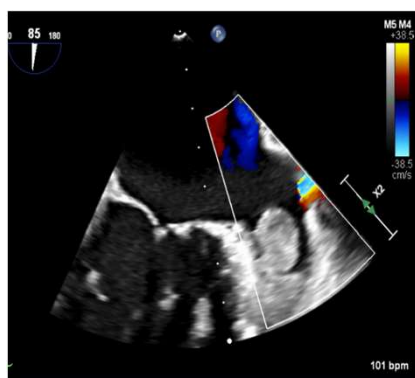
Large Left Atrial Appendage Thrombus on Echocardiogram.
